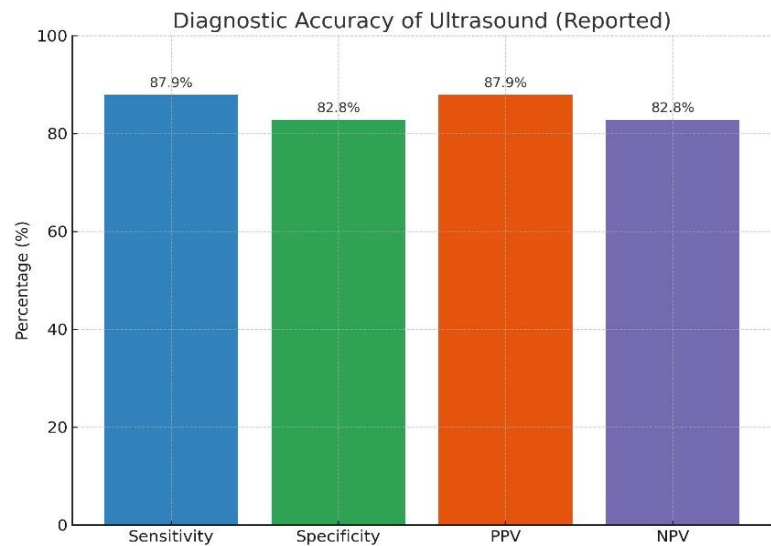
Diagnostic Accuracy of Ultrasound (Reported)
